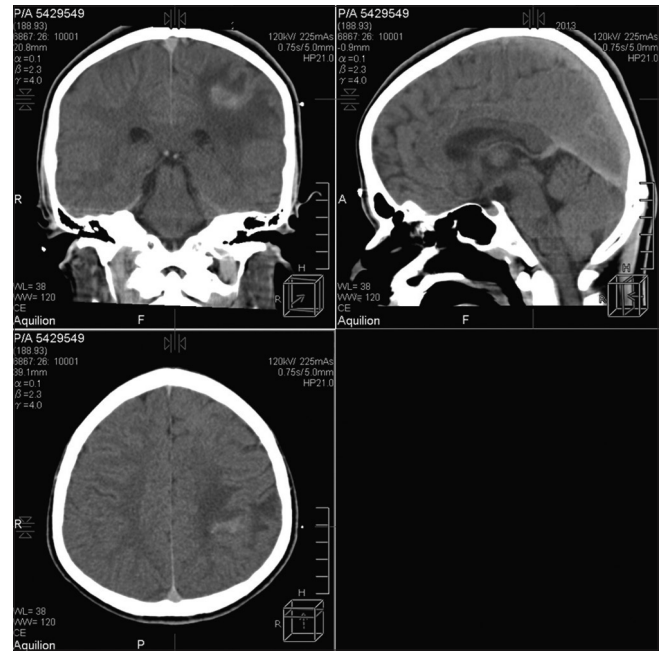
Preoperative computed tomography showing the left parietal enhancing lesion with the marker over it
